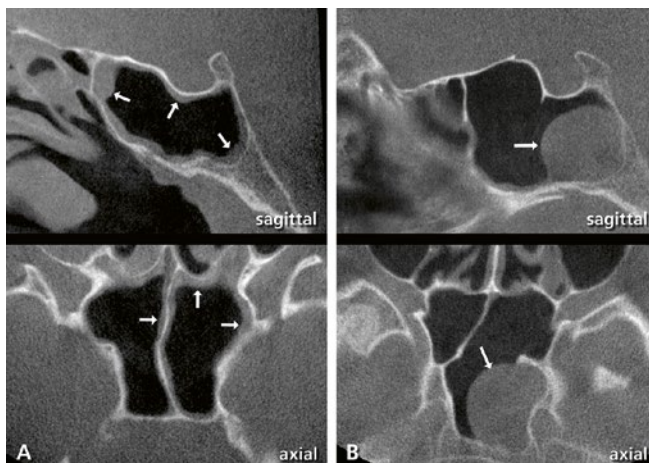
CBCT images with pathologies inside the SPS (sagittal und axial views): A = mucosal thickening; B = mucous retention cyst
